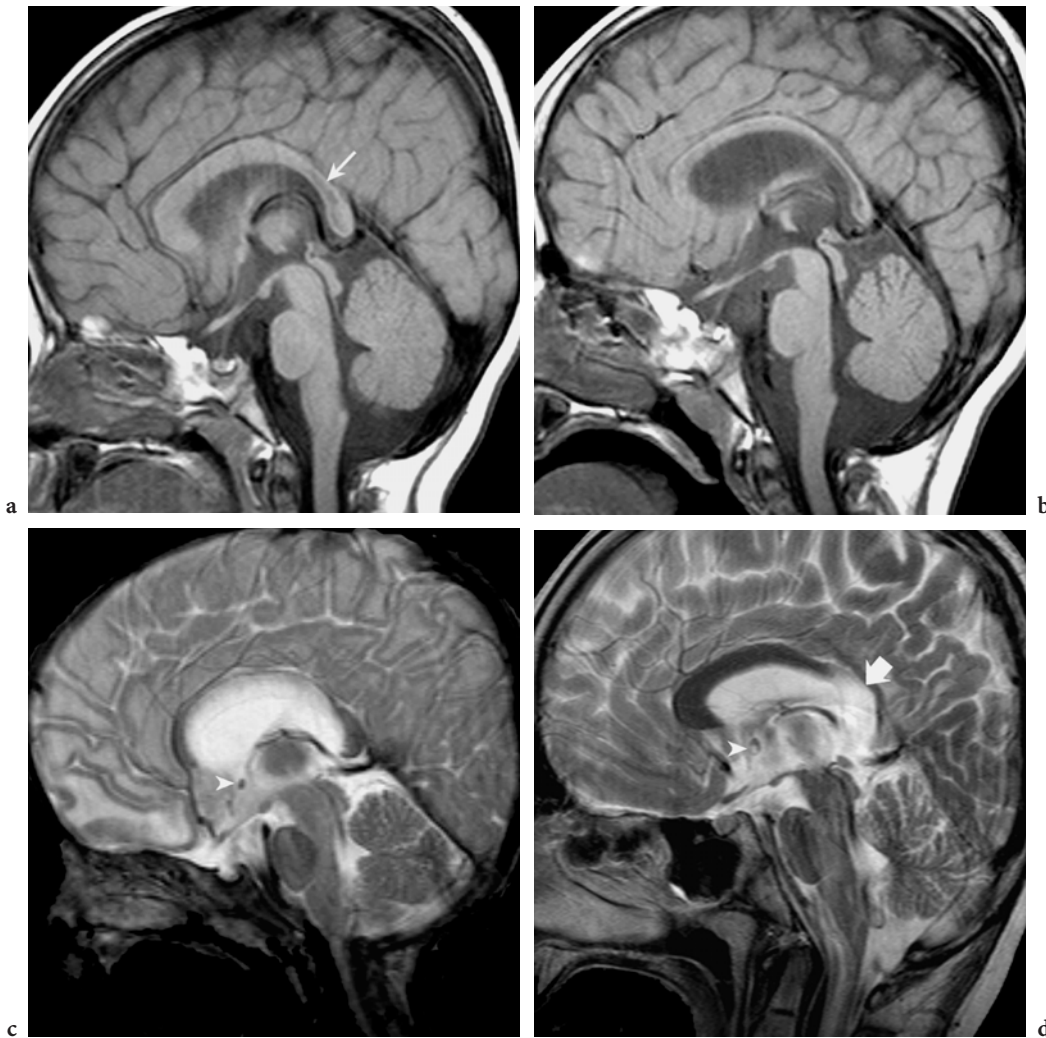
Patterns of involvement of the corpus callosum in various leukodystrophies. a Sagittal T1-weighted spin-echo image in a 2-year-old female patient with metachromatic leukodystrophy. At this stage of the disease the anterior parts of the corpus callosum exhibit some swelling, whereas posteriorly atrophy and ill-defined hypointensities (*arrow*) are seen. This is consistent with the known postero-anterior progression gradient of the demyelinating process. b Sagittal T1-weighted spin echo in the same patient at 4 years of age. By this time, the entire corpus callosum shows atrophy and signal changes, which are, however, more prominent posteriorly. c Sagittal T2-weighted gradient echo image in a 19-month-old female patient with van der Knaap disease. The most prominent signal changes are seen at the level of the inferior aspect of the body of the corpus callosum; the upper margin as well as the knee and the splenium show partial sparing. Note the sparing of the anterior commissure (*arrowhead*). d Sagittal T2-weighted fast spin-echo image in a 12-year-old male patient with X-linked adrenoleukodystrophy. At this stage of the disease, the signal changes involve the splenium and the posterior part of the body only (*arrow*). Note the signal abnormalities within the anterior commissure (*arrowhead*)
